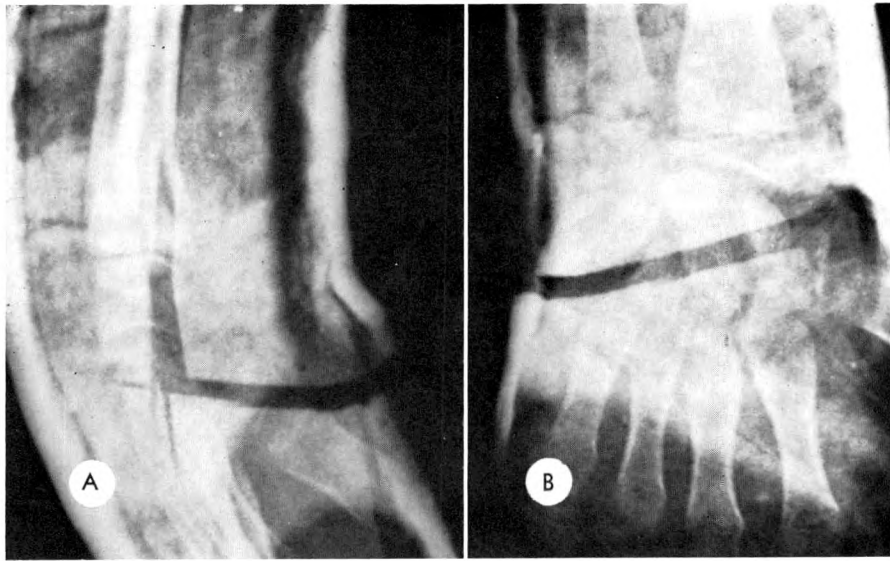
Case 1. (A) Lateral and (B) posteroanterior roentgenograms taken through plaster cast after reduction demonstrate good position and alignment.
